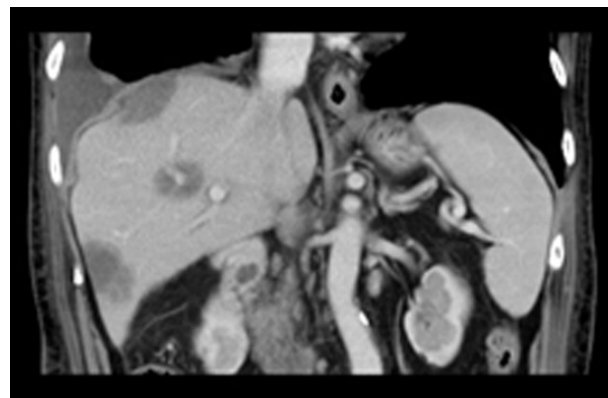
Multiple Focal Liver Lesions in Patients with AIDS-Related NHL appear on Contrast-Enhanced CT Scans as Low-Density Lesions
